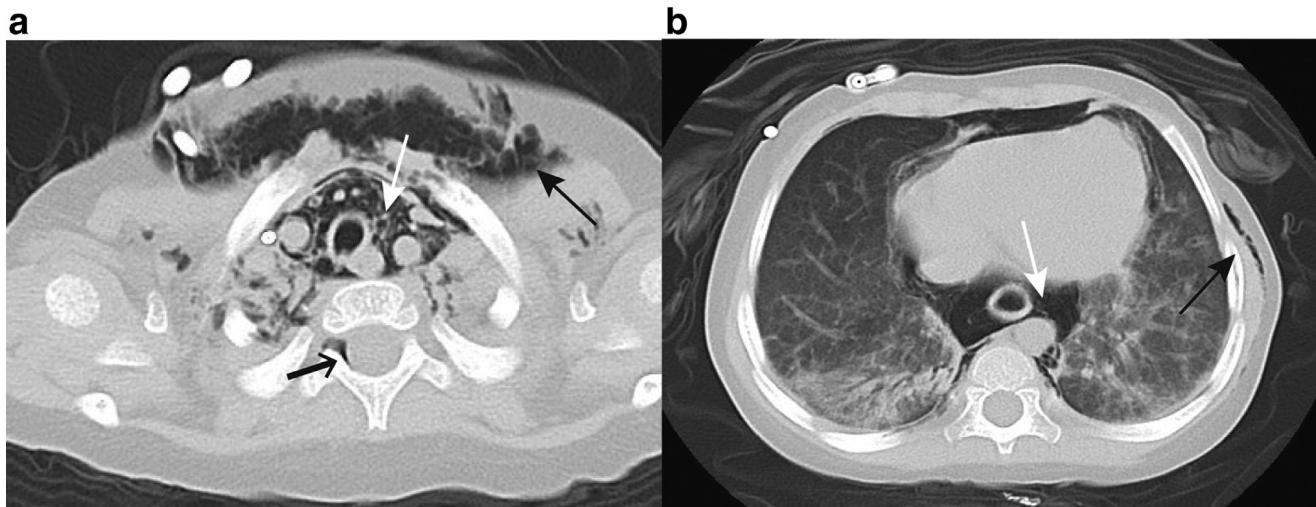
Computed tomography findings at admission of a 3-year-old boy with pneumorrhachis.
